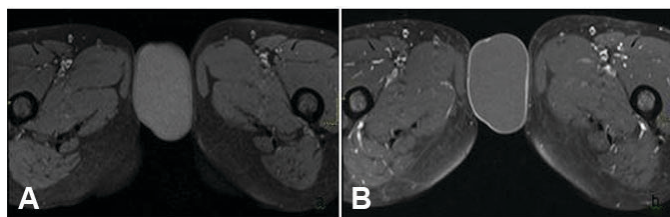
MRI images taken on (A) diffusion weighted imaging (DWI) and (B) apparent diffusion coefficient (ADC) demonstrate that the lesion returns high intensity signals on DWI and low intensity signals on ADC, i.e., showing diffusion restriction, which is a characteristic feature of epidermoid cysts.
